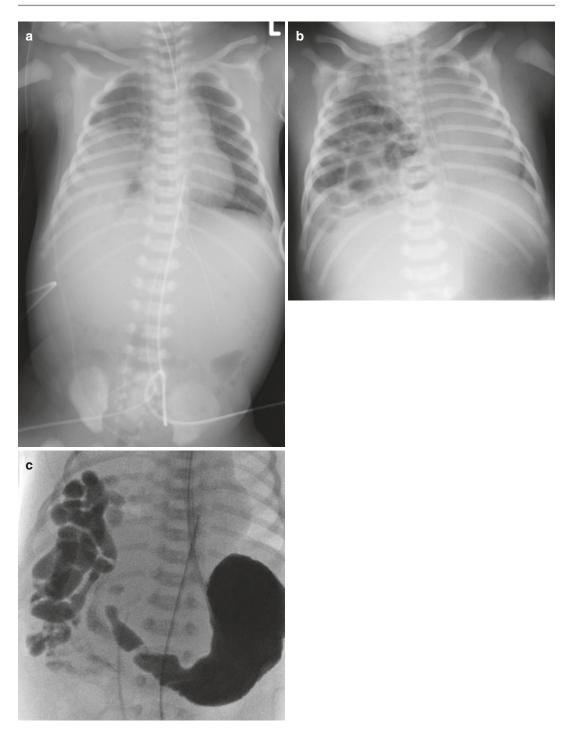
Congenital diaphragmatic hernia. Neonate presenting with respiratory distress. Initial plain film early post delivery (a) demonstrates opacity in the right mid and lower zones, with absence of the normal outline of the right hemidiaphragm. The tip of the NG is well below the left hemidiaphragm. Note the low position of the umbilical venous catheter. Film 6 h later (b) shows marked mediastinal shift to the left and multiple air filled lucencies in the right hemithorax. The NG tube is displaced to the left in the thorax and the tip is seen to lie in the region of a distended gas filled stomach. Selected image from a water soluble upper GI contrast study (c) shows the normally positioned stomach to fill with contrast. The duodenum is seen to pass to the right of midline and contrast is seen in multiple loops of intrathoracic jejunum
